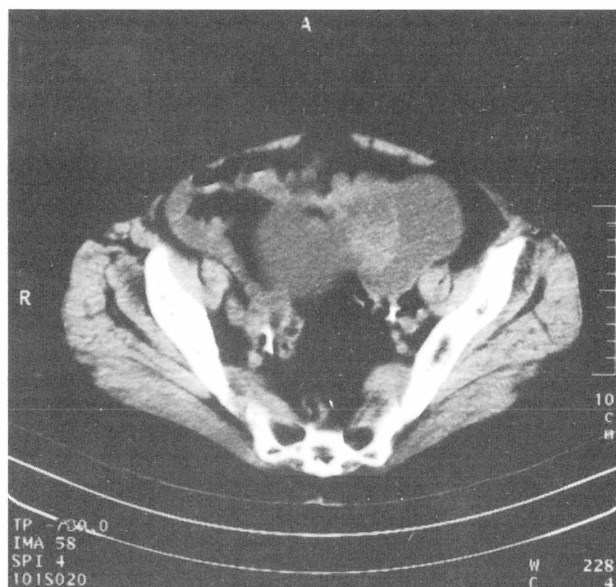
CT finding on admission: isolated metastasis of a squamous cell carcinoma of the cervix uteri to the left ovary with a diameter of 8.5 cm.
